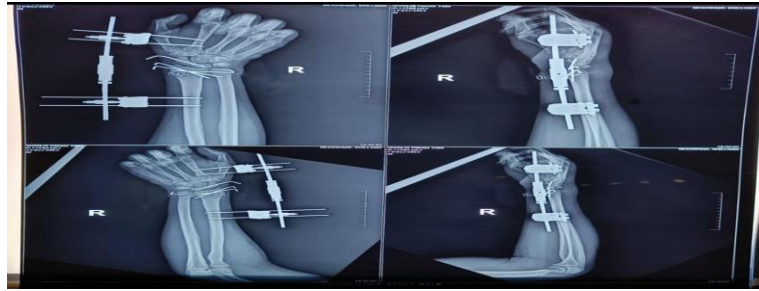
Post operative xrays on day 3
